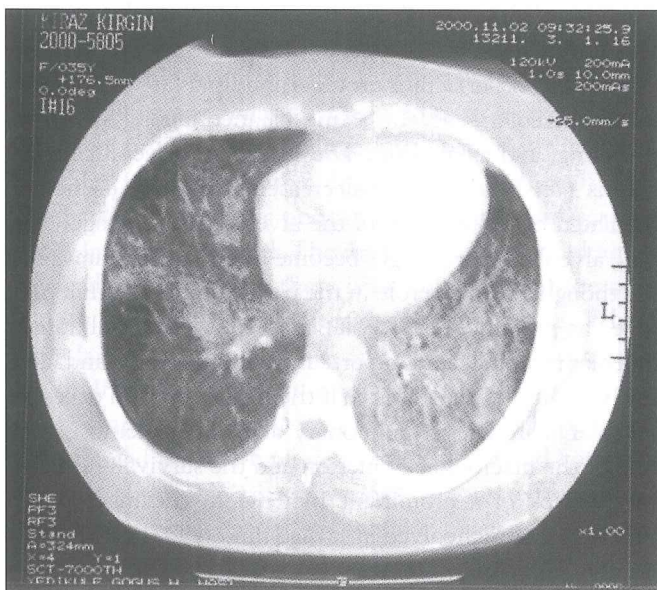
Chest CT scan revealing diffuse ground glass opacity with well bordered interstitial structures and affect the subpleural areas.
